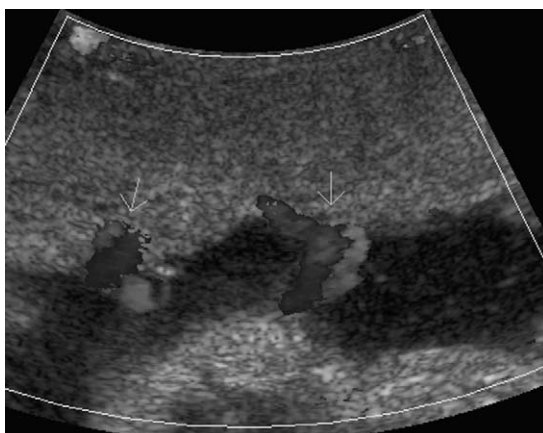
Cord insertions in close proximity in a monoamniotic pregnancy using color Doppler.
